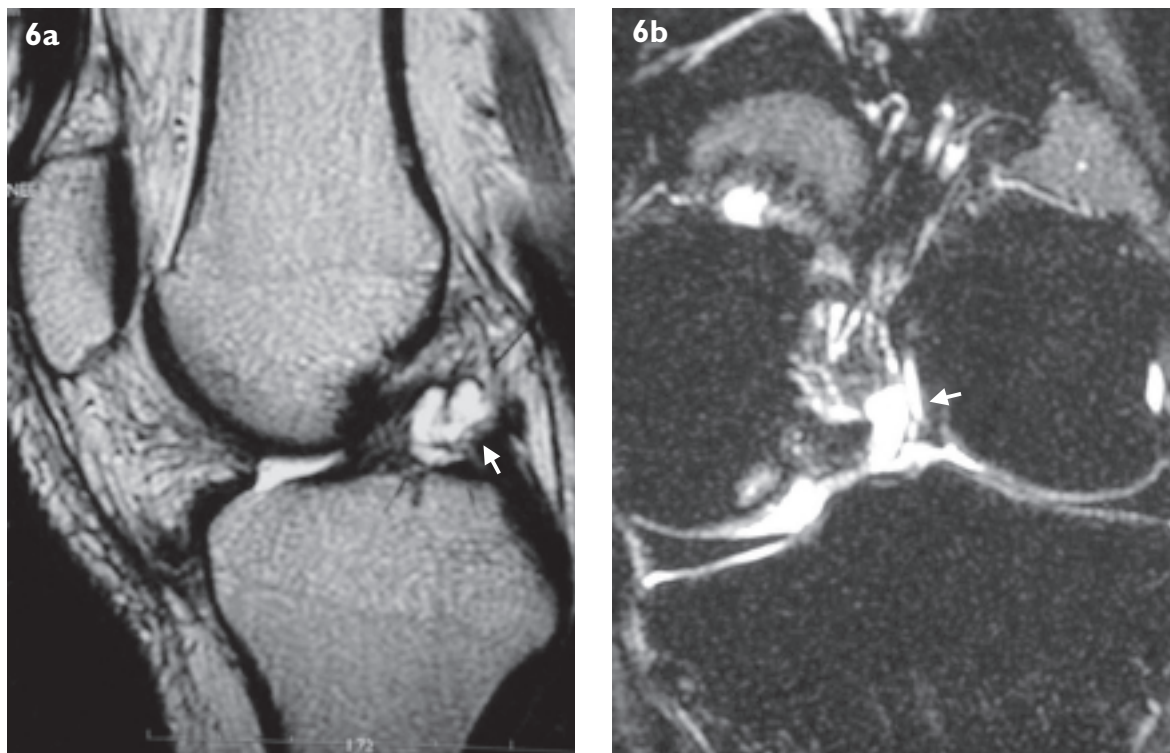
Intra-articular ganglion. (a) Sagittal T2-weighted and (b) coronal fat suppressed T2-weighted MR images show a well-defined lobulated and septated cystic lesion (arrow) in the anterior cruciate ligament.
